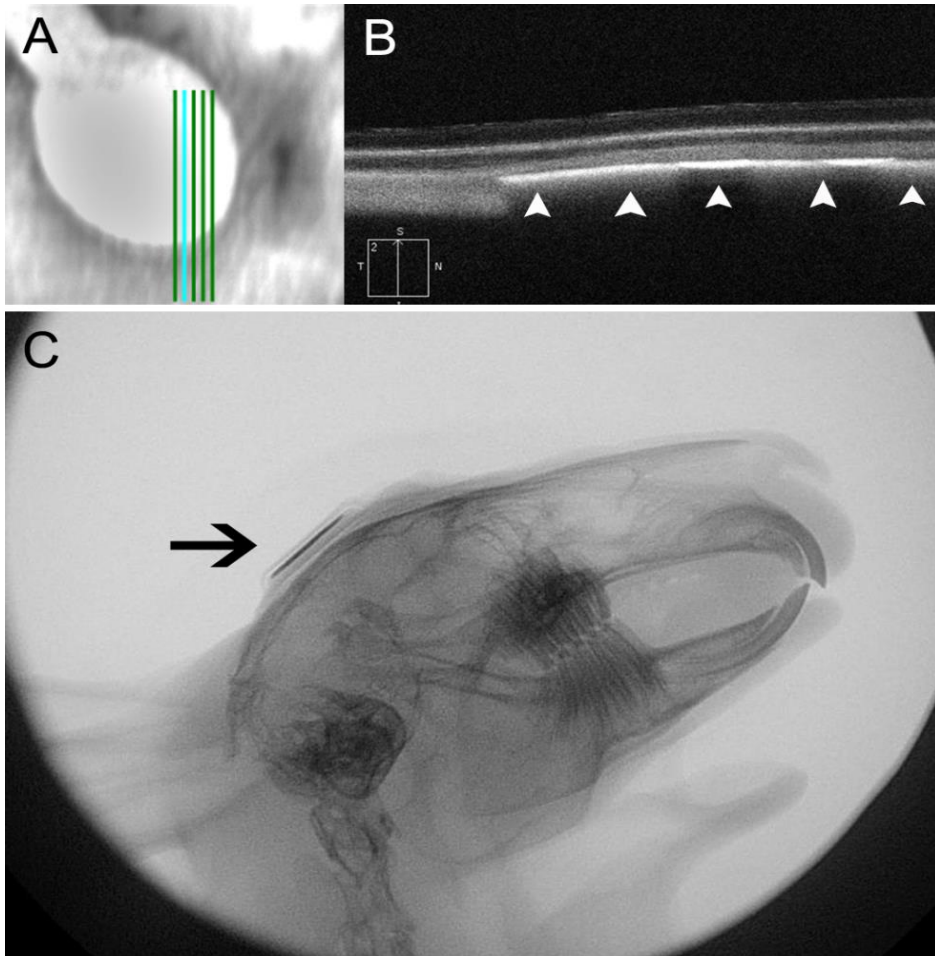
The images of optical coherence tomography (OCT) and x-ray of implanted prototype retinal prosthesis at 10 months after implantation surgery. (A) The blue line of infrared fundus image shows the direction of the OCT scan. (B) The cross-sectional OCT image represents successfully implanted electrode array (white arrowhead) in the suprachoroidal space without any damages of retina or choroid. (C) Lateral view of skull x-ray shows proper position of system package (black arrow) on the skull.
